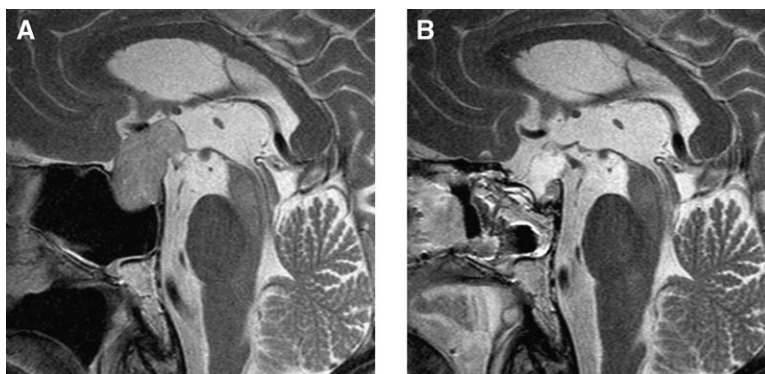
(A) Preoperative T2-weighted imaging in a 53-year-old man with a pituitary adenoma with a distinct suprasellar extension. (B) Intraoperative imaging confirms complete removal.
